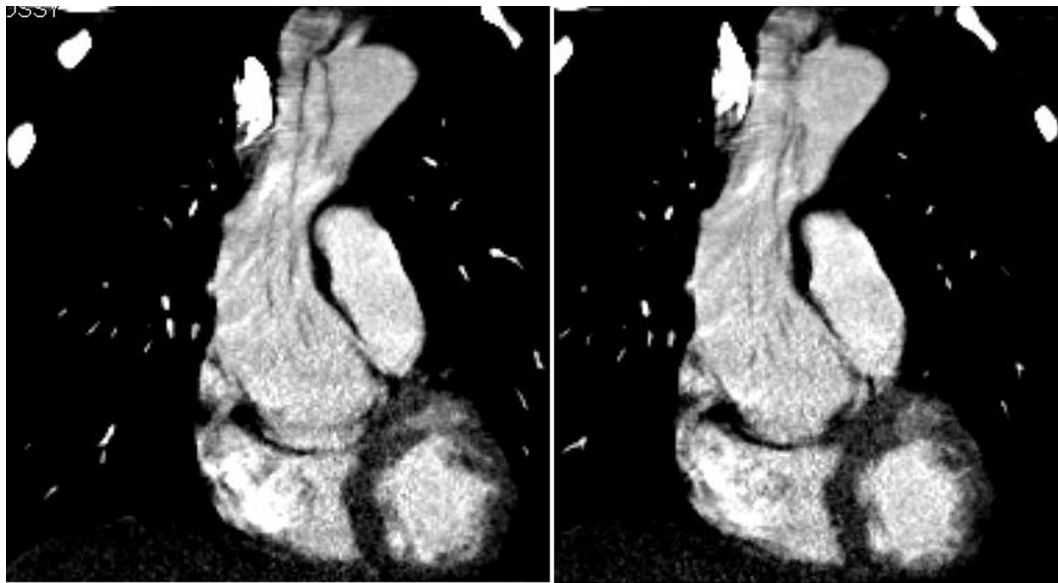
Computed tomography of chest, abdomen, and pelvis revealing Stanford type A aortic dissection with contained rupture and aortic root dissection extending into the right common carotid artery.
